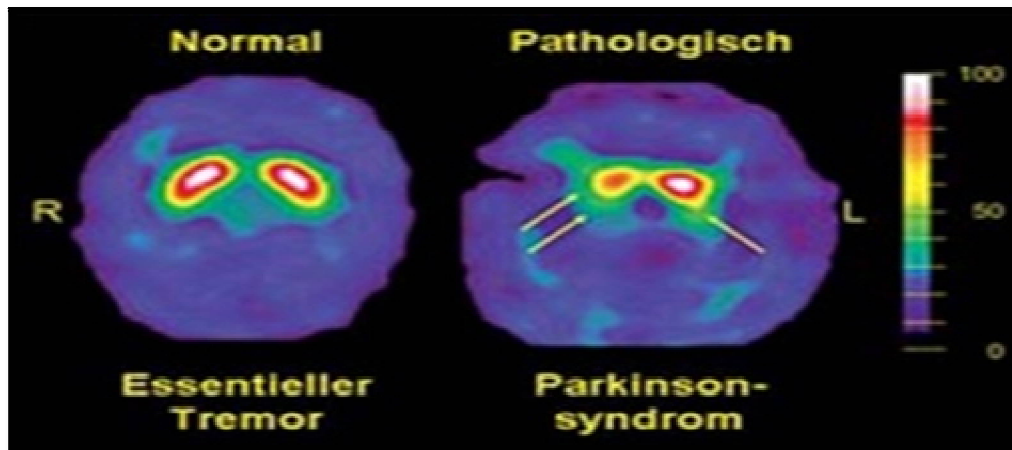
A SPECT Camera Showing DAT Scan and It Displays Essential Tremor on the Left (Normal DAT), and a Parkinson Syndrome on the Right (Decreased DAT)
